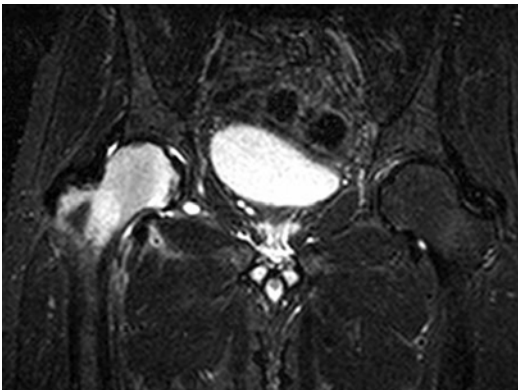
Transient osteoporosis on right femoral neck on FS T2-weighted coronal image. Homogeneous high signal intensity is revealed
